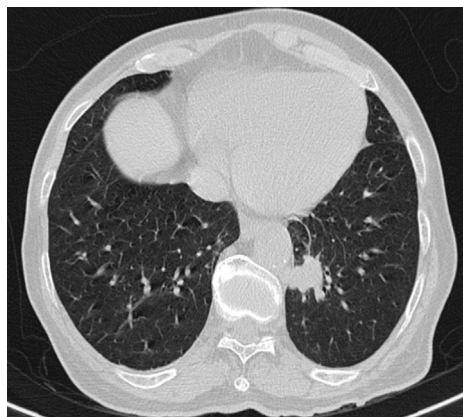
Chest CT image from a 69-year-old patient with psoriasis and psoriatic arthritis after 4 months of adalimumab treatment. CT image shows approximately 4.5-cm nodular opacity with soft tissue density in the basal anteromedial segment of the lower left lobe.
